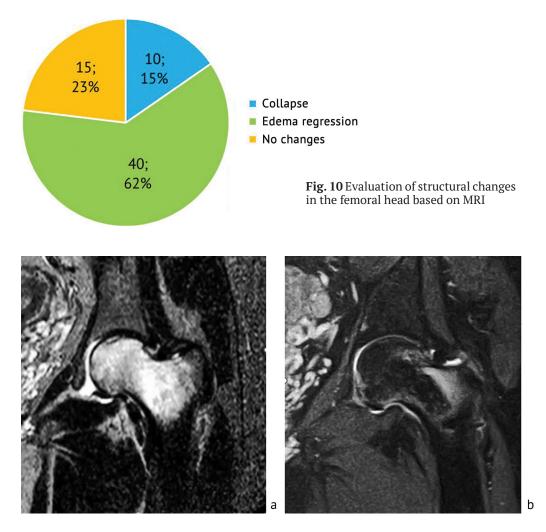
MRI image of the hip joint of patient T., 45 years old, with ANFH: a before surgery; b 6 months after treatment
